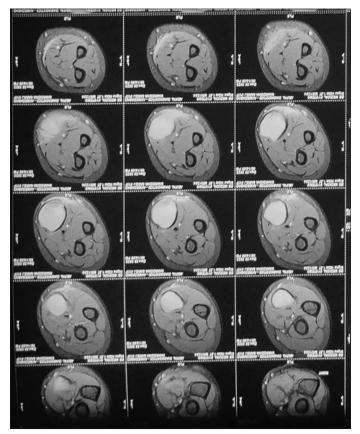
Magnetic resonance imaging scan of forearm suggestive of intermuscular cysticercosis with surrounding abscess
